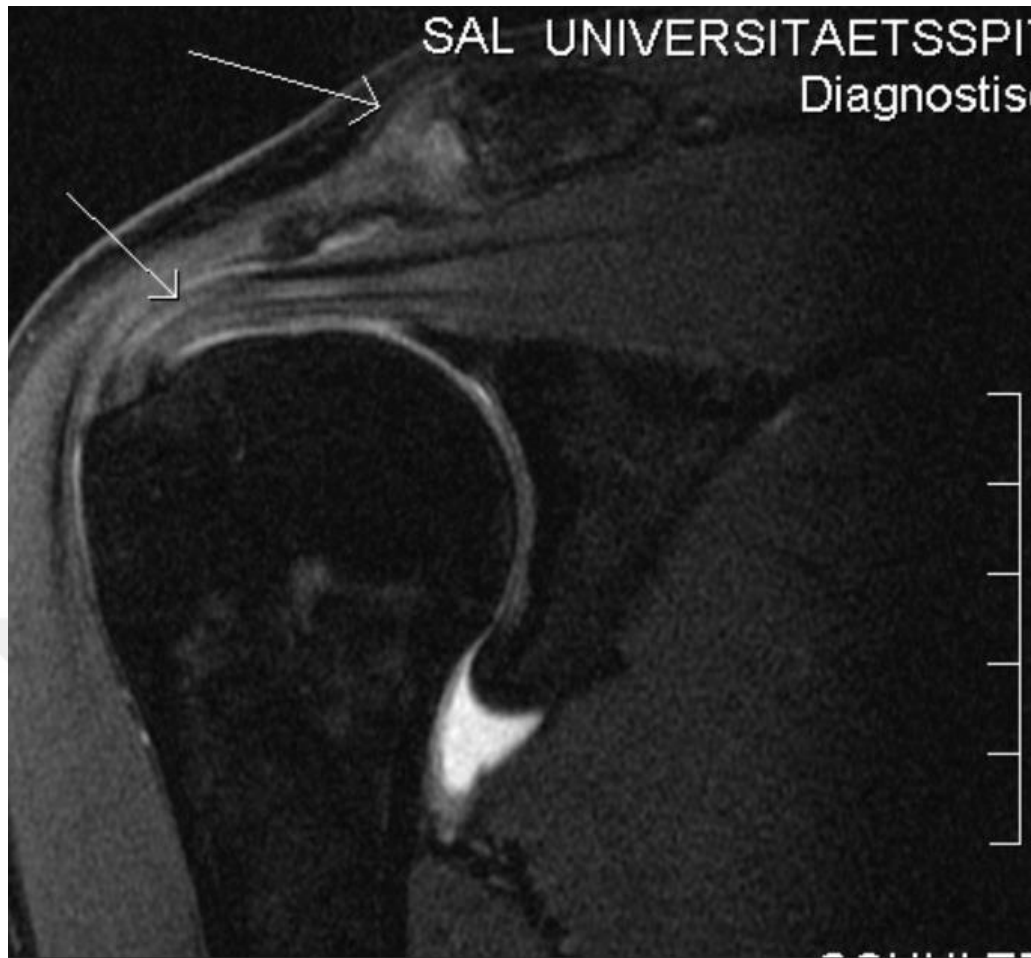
MRI Imaging in SIS (A Partial Rupture of Supraspinatus Tendon) (29).
